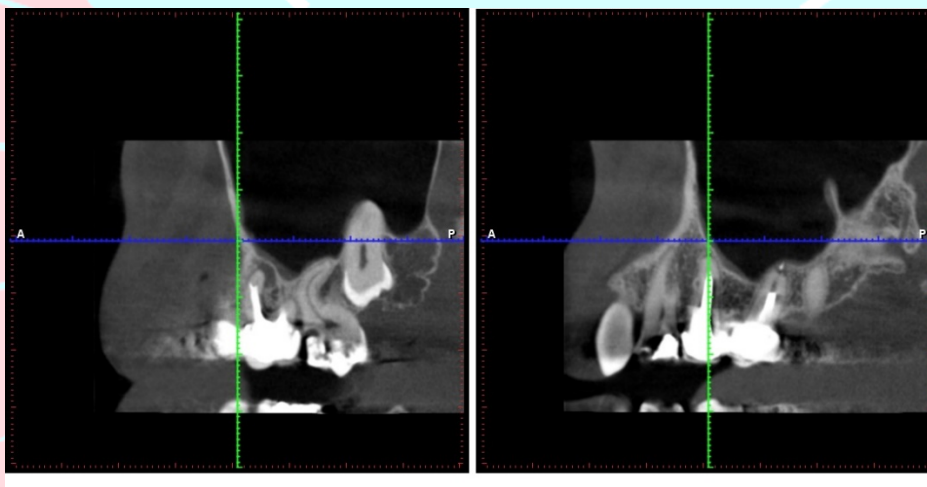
Computed tomography – medial and palatal root of tooth 26
